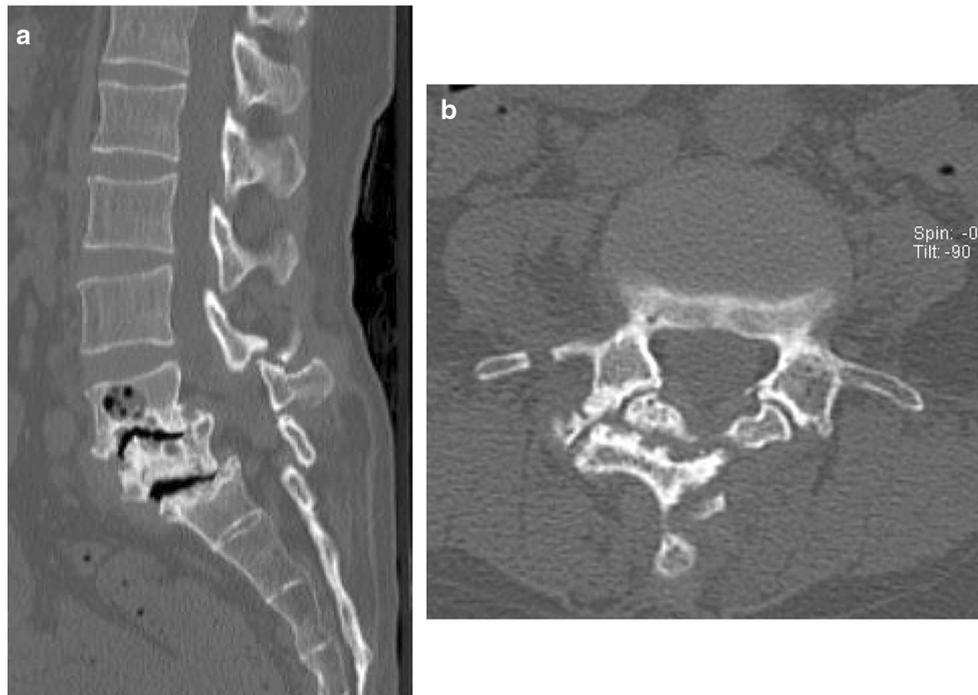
Computed tomography with sagittal (a) and axial (b) scans shows intradiscal vacuum and destruction of endplates and facet joints
